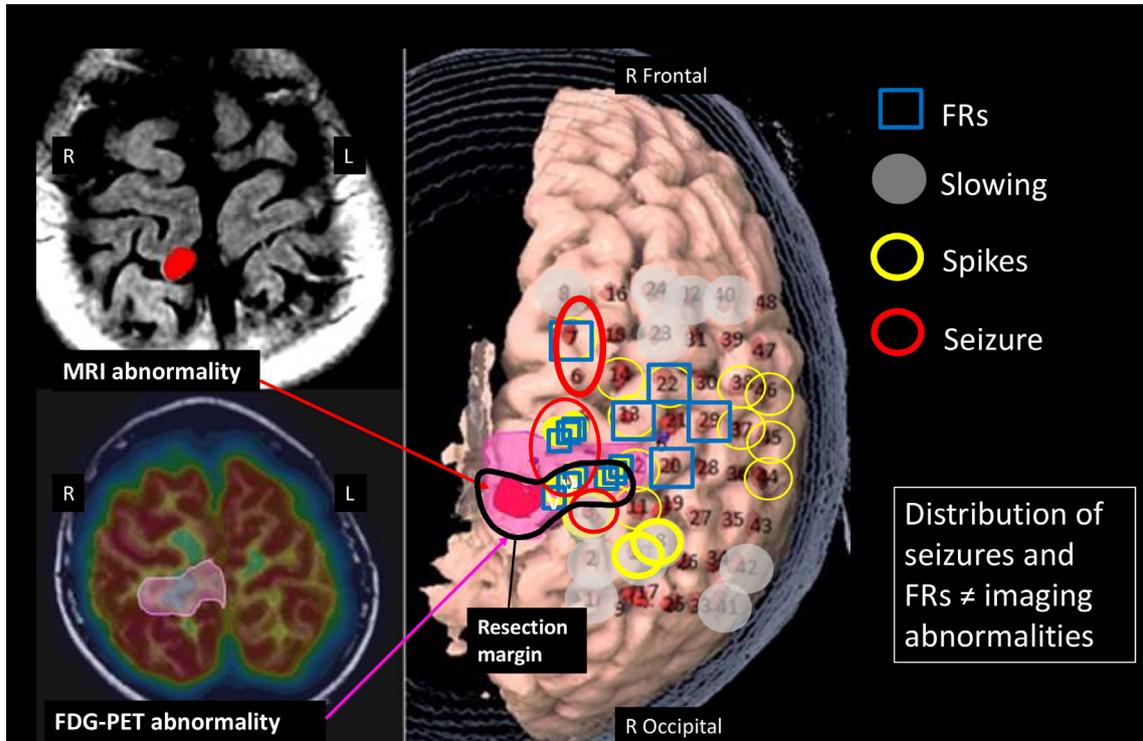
Example of fast ripples (FRs) and neuroimaging abnormality mapping. An example of FRs and neuroimaging abnormality mapping is shown (patient #9). Distribution of neurophysiological abnormalities including FRs, slowing, spikes, and seizures (onset) is mapped onto the patient's reconstructed three-dimensional brain MRI. A region circled with a pink line indicates FDG-PET hypometabolism, and a small red-shaded area indicates a brain MRI structural abnormality noted by a neuroradiologist. A brain MRI structural abnormality was taken, yet some seizure onset zones and FDG-PET hypometabolism were left behind. This patient had immediate seizure recurrence after the resection. Please note topographic distribution of interictal FRs extends beyond neuroimaging abnormality and localized differently to seizure onset zones.
